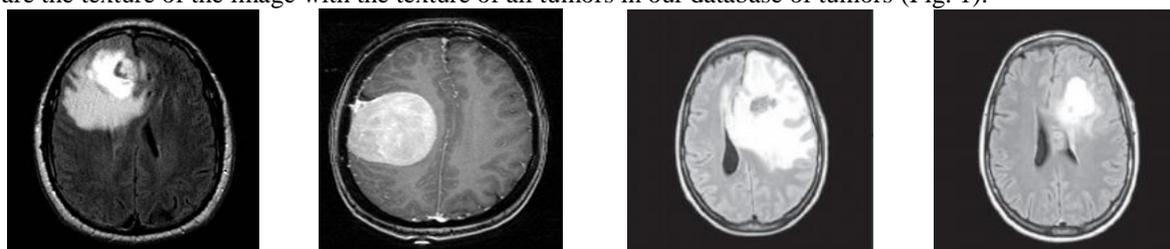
MRI-T1 (left) and T2 images (right) contain different types of tumors.
